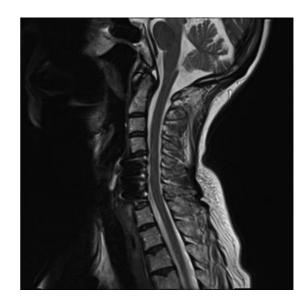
T2-weighted sagittal magnetic resonance imaging performed 6 months postoperatively after patient presented with recurrent symptoms. Note that no persistent and/or recurrent stenosis apparent at the C5–C6, C6–C7 level.
